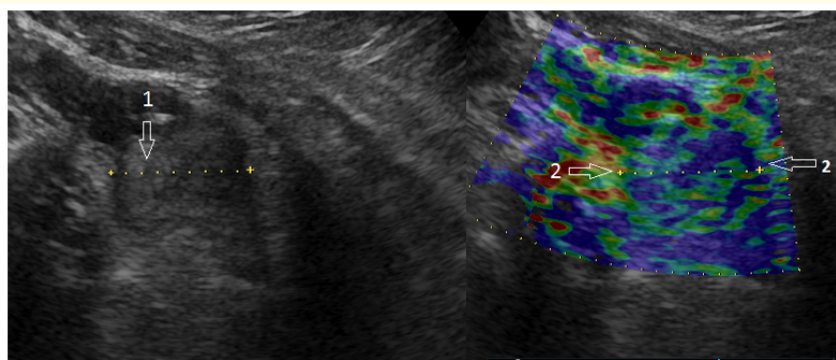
Ultrasonic tomogram of the metastatic tumor of the left ovary patient D diagnosed with moderately differentiated endometrioid endometrial adenocarcinoma with squamous cell differentiation: 1- metastatically altered ovary; 2- compression elastography regimen.
